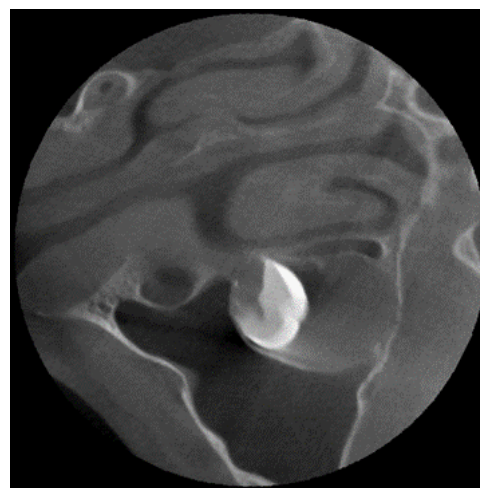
CT Cone-Beam axial view, Neurilemmoma surrounding molar and reaching maxillary sinus walls without involving sinus mucosa.
